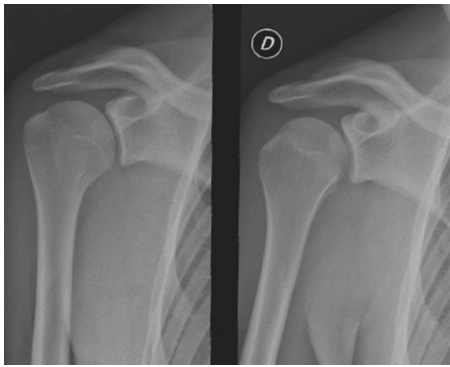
Anteroposterior radiograph of the right shoulder from the first admission.
